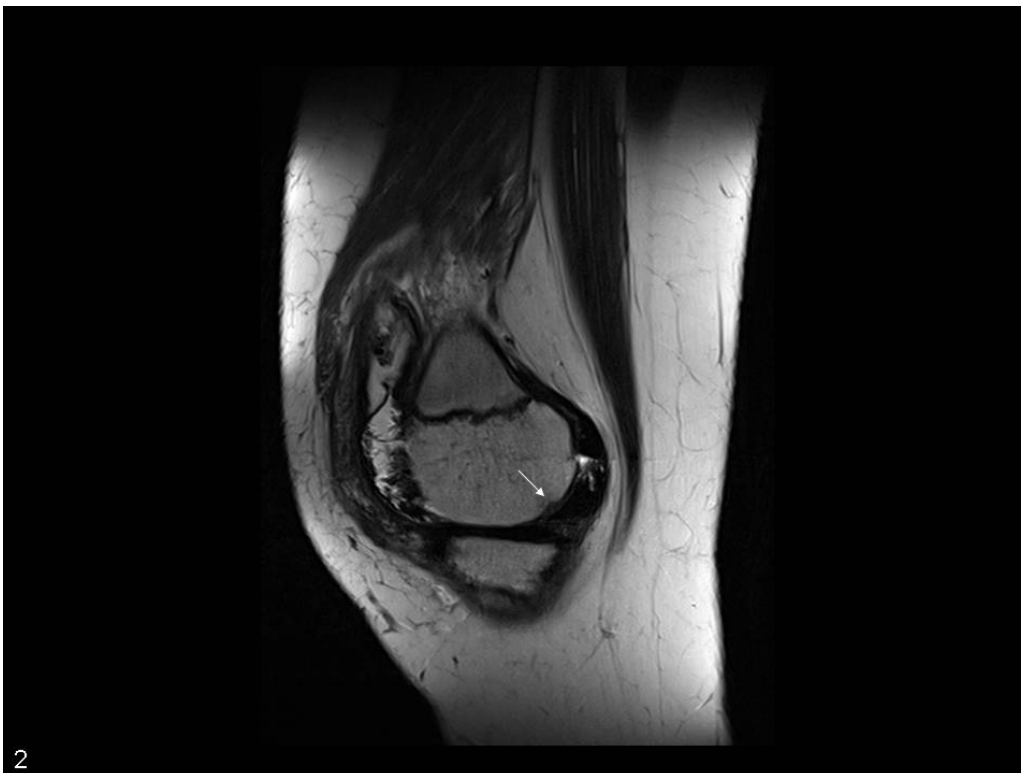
Sagittal PD-weighted TSE MRI. Erosion of the anteriomedial femur condyle is shown (arrow).
